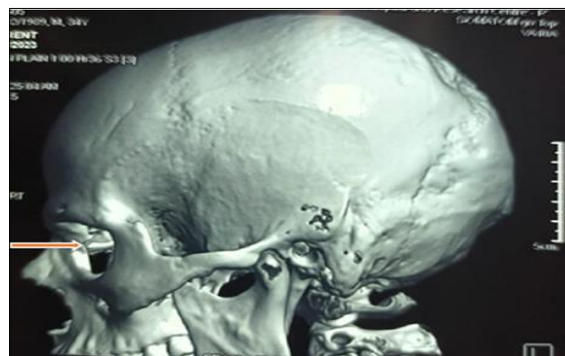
3D reconstruction of CT skull shows foreign body in right orbit (arrow)
